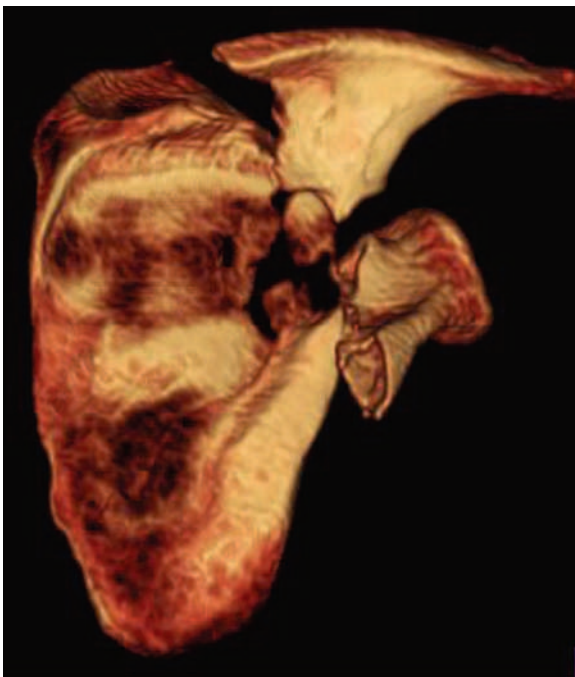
Three-dimensional computed tomography view of scapula fracture. Complete disassociation of the glenoid from the scapular body is present.
